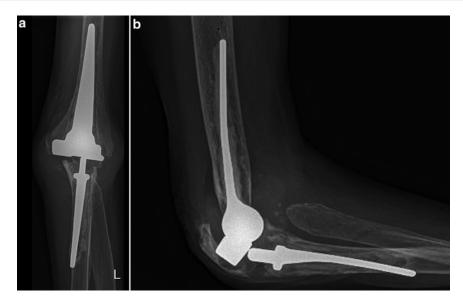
(a, b) Eleven years post-TEA, the radiographs show decoupling of the two components and perforation of the ulnar stem through the posterior cortex. Furthermore, there is discontinuity of the extensor apparatus due to an
